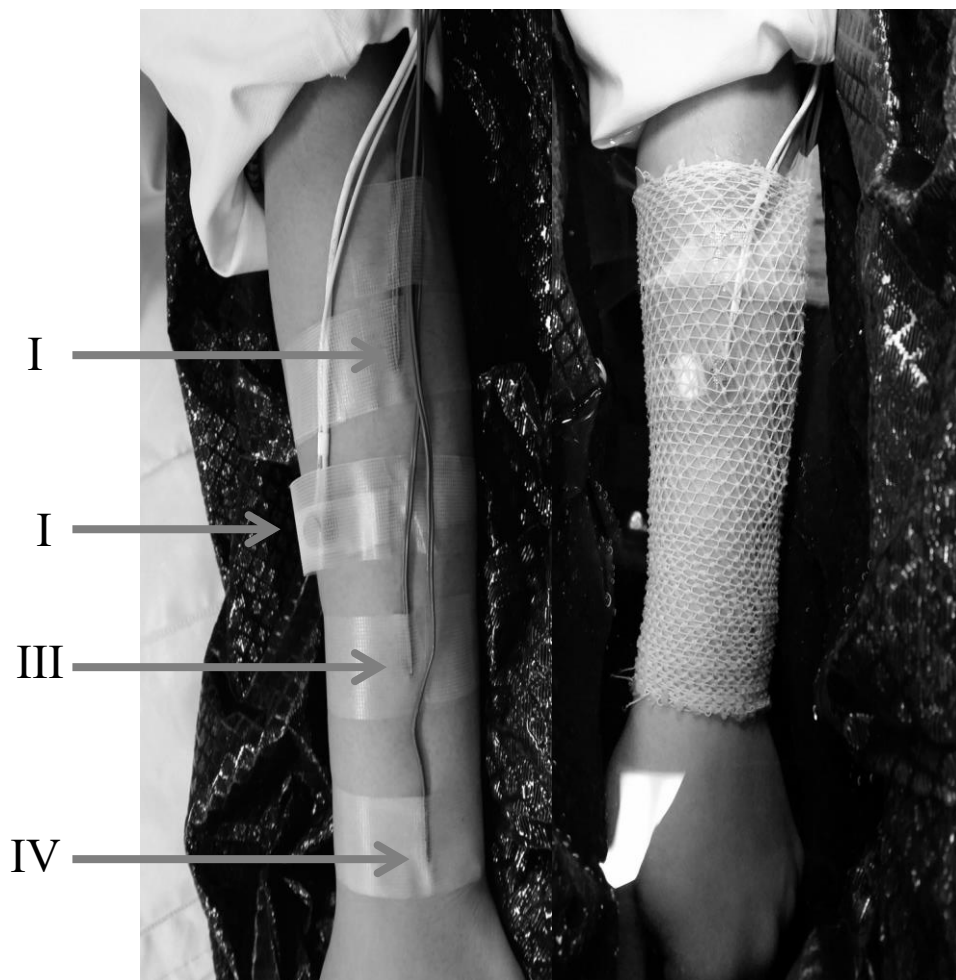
The left panel is the forearm instrumented. I is the laser-Doppler probe, II-IV are proximal (II), middle (III), and distal (IV) thermocouples used to calculate mean forearm temperature. The right panel is the forearm submerged and positioned for the duration of the experiment.
